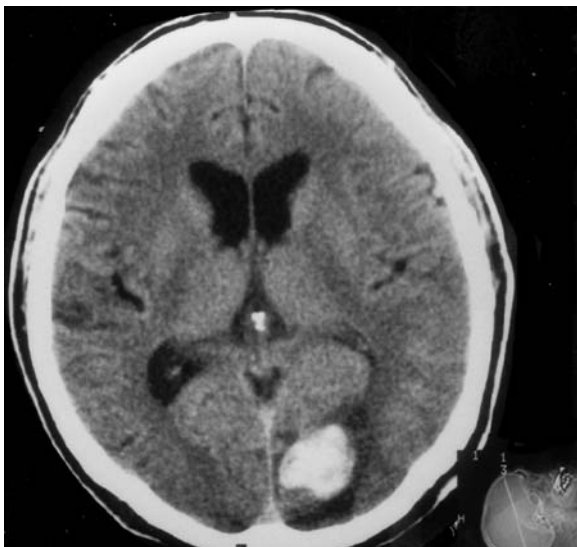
CT of a 74-year-old man with acute hemianopia to the right side. Diagnosis: acute, spontaneous hemorrhage of the left occipital lobe
